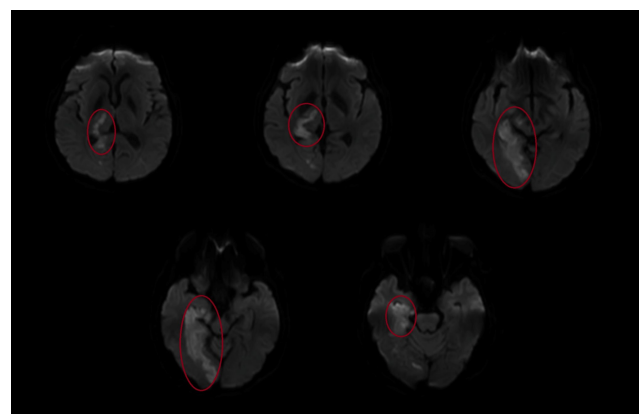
MRI-DWI of AIS patient with left MCA infarction. Hyperintense areas (red circle) are denoted as infarctions.
